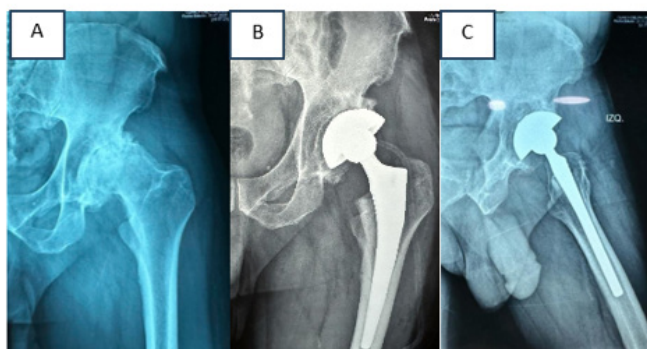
Preoperative radiograph prior to cementless left total hip replacement (A). Postoperative AP (B) and lateral images show evidence of acetabular cup protrusion (C).
